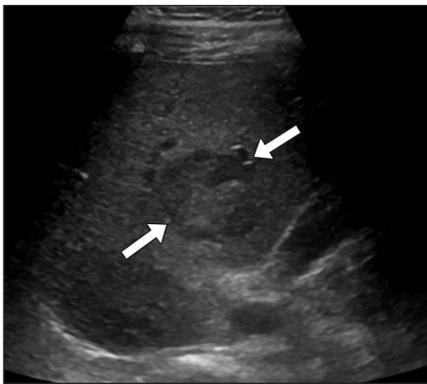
17-year old girl with history of Ewing sarcoma of left iliac wing and liver lesion detected at follow-up spinal MRI (not shown).
